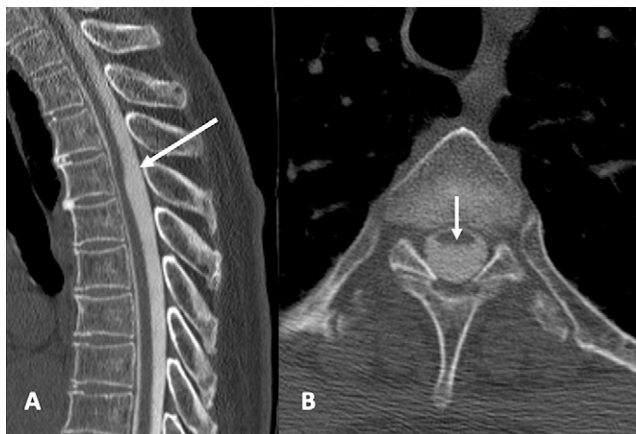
CT myelography of the thoracic spine. A: Sagittal reconstruction clearly shows the scalpel sign (arrow). B: Axial imaging shows anterior cord displacement and severe flattening of the posterior aspect of the cord without evidence of a detectable mass (arrow).
